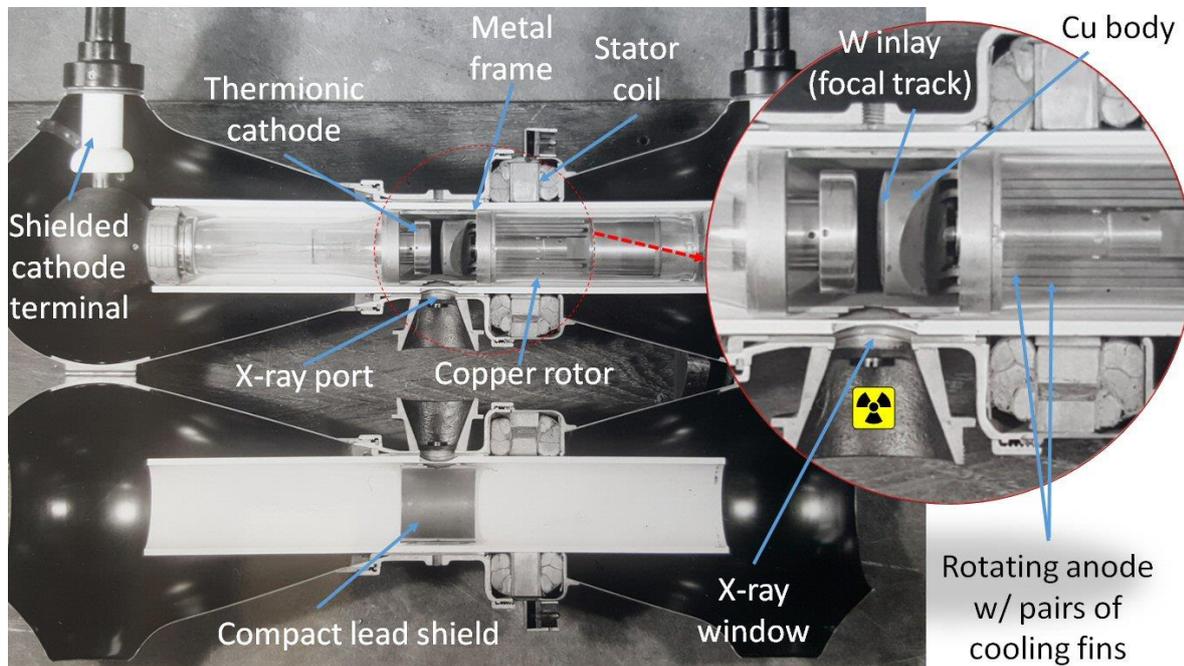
Cut out model of the first industrialized rotating anode tube in Figure 12 (d). It allowed better heat dissipation at moderate temperatures, which otherwise the copper anode material restricted, A. Bouwers attached cylindrical cooling fins to the rotor, interleaved with stationary fins. Varian (now Varex), Salt Lake City, UT, USA, employed this concept again from the late 1990's for the MCS 7xxx CT tube series. Philips marketed the Rotalix™ tube as “fully” protected against leakage radiation and electrical shock. It was rated with peak power of up to 30 kW in a 2 mm wide focal spot (area 15 mm², focal track radius 2.5 cm, 20 Hz rotor frequency). Compared with the stationary anode Metalix™ (predecessor tube), the Rotalix™ tube featured a 9-fold improvement of the power rating, see also [9], figure 6.43.
